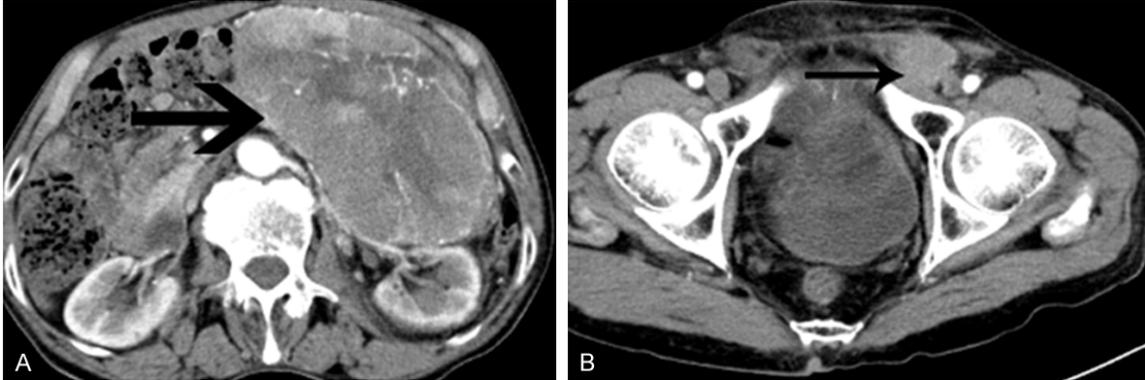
Computed tomography (CT) scan showed an 20*15*12 cm retroperitoneal tumor (A) with an enlarged left inguinal lymph node (B).
